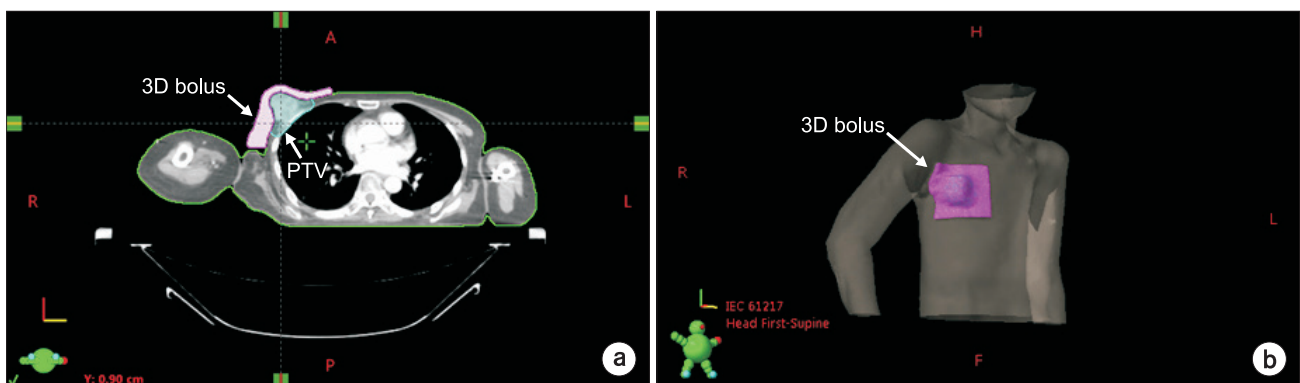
(a) Transaxial view of patient CT and designed bolus and (b) volume rendering of designed bolus.
